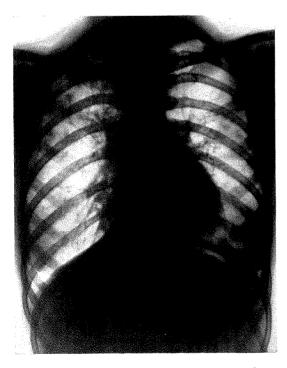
Roentgenogram of March 21, 1939, almost complete disappearance of the fibria body.
